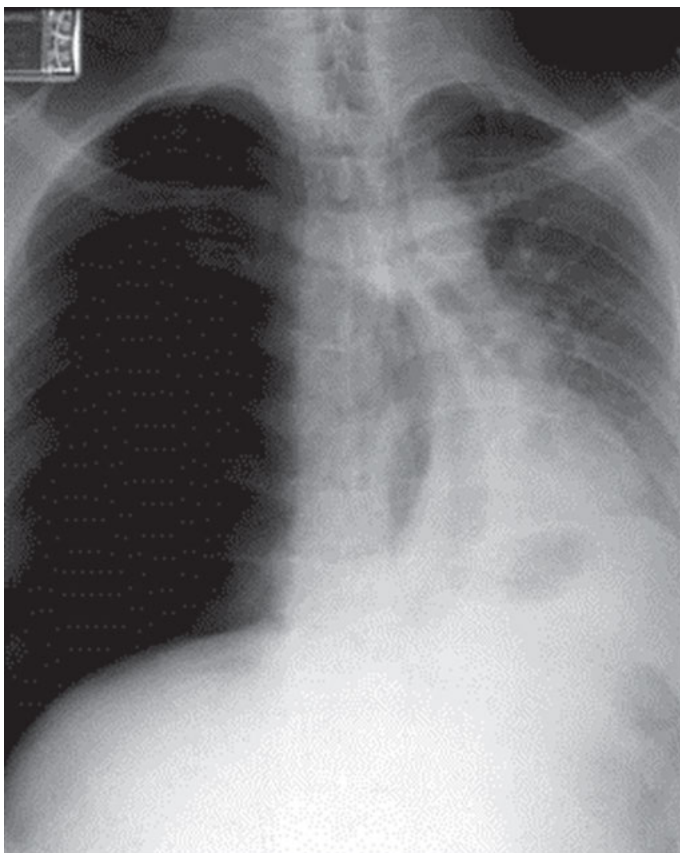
Example of a radiograph with a right-side tension pneumothorax.
